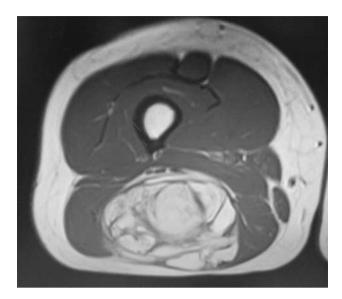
Example of septation. The image presents a palpable mass in the posterior thigh of a 54-year-old female patient who was diagnosed with well-differentiated liposarcoma. The formation of multiple septa was detected in the T1-weighted image.
